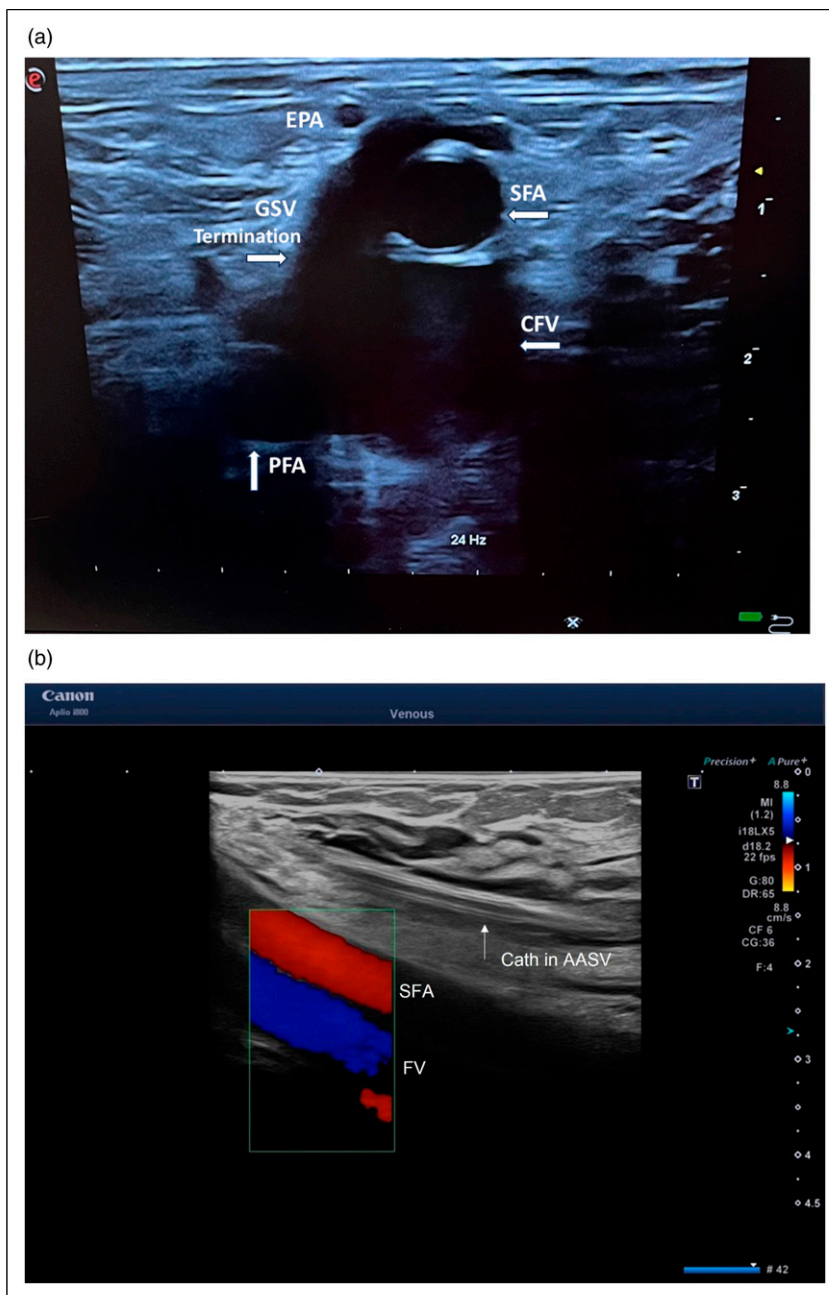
Superficial position of the superficial femoral artery (SFA) (A) Duplex ultrasound of the right groin (transverse view), showing a rare anatomical variation of the termination of the great saphenous vein (GSV) into the common femoral vein (CFV), laterally from the superficial femoral artery (SFA). Note the superficial position of the SFA and the external pudendal artery (EPA). PFA, profunda femoris artery (ultrasound image courtesy of Dr Pauline Raymond-Martimbeau, Canada). (B) Duplex ultrasound of the right groin (longitudinal view) demonstrating the positioning of a catheter (CATH) in the anterior accessory saphenous vein (AASV) in close proximity to the SFA which is shown to overly the femoral vein (FV) (image courtesy of Prof. Kurosh Parsi).
